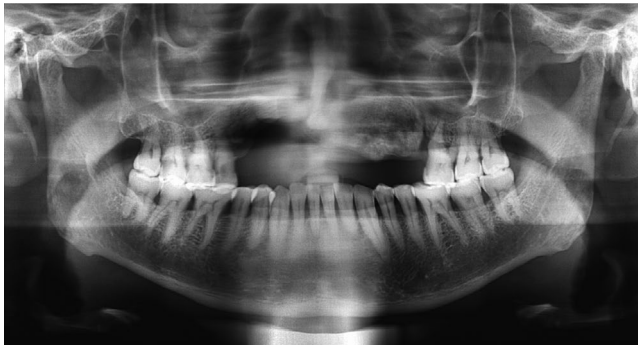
Digital panoramic radiograph showing the lesion at anterior maxilla with a well-defined distal margin with a narrow zone of transition and surrounded by a radiolucent halo. The adjacent tooth 26 showed widening of periodontal ligament space
